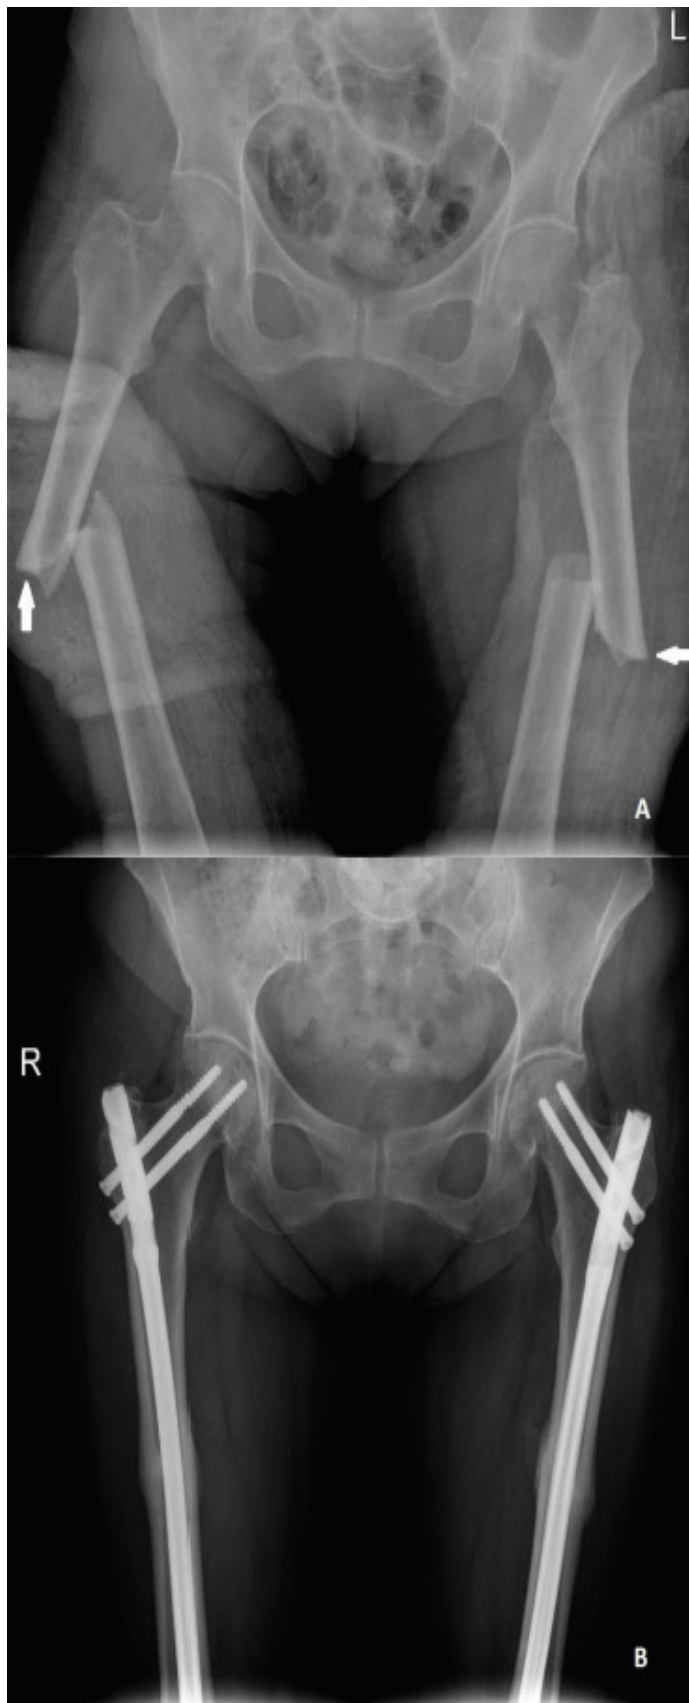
Bilateral atypical femur fracture (AO/OTA 32A3) A. Pre-operative anterior–posterior (AP) plain radiograph of the patient. White arrows show cortical thickening at the femoral shaft. B. AP plain radiograph of the patient at 6-month postoperatively which show fracture healing
